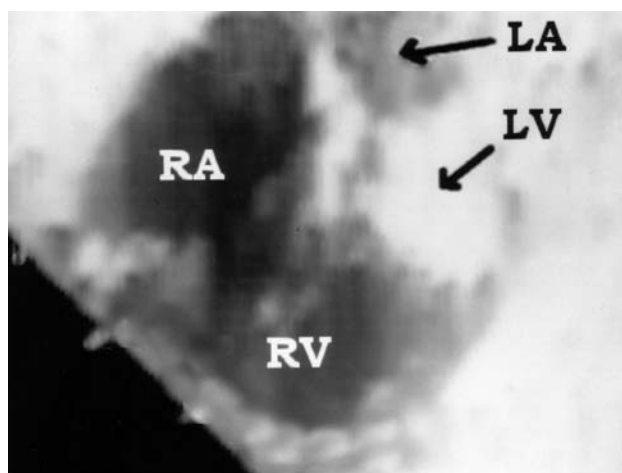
Frame of a fetal echocardiogram, at 18 weeks' gestation, in four-chamber view, showing gross hypoplasia of the left ventricle with obliteration of the cavity.
